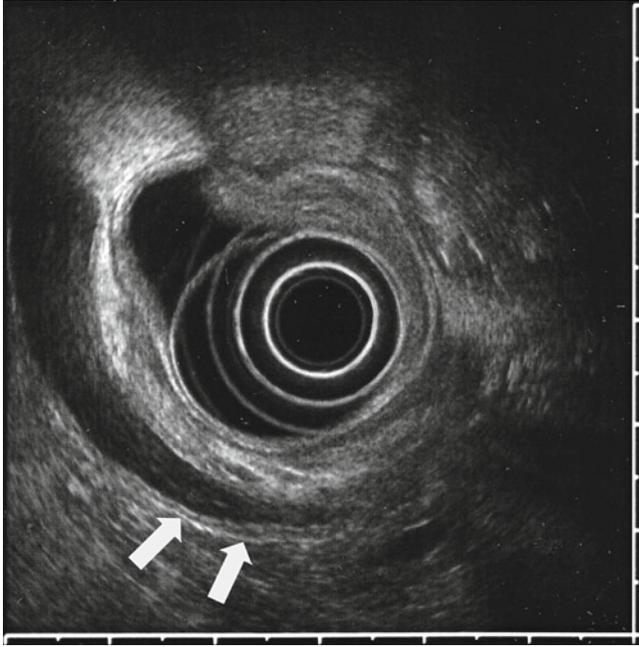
Radial EUS image (12 MHz) showing the three endosonographic layers of the common bile duct, best identified at high frequencies (arrows).
